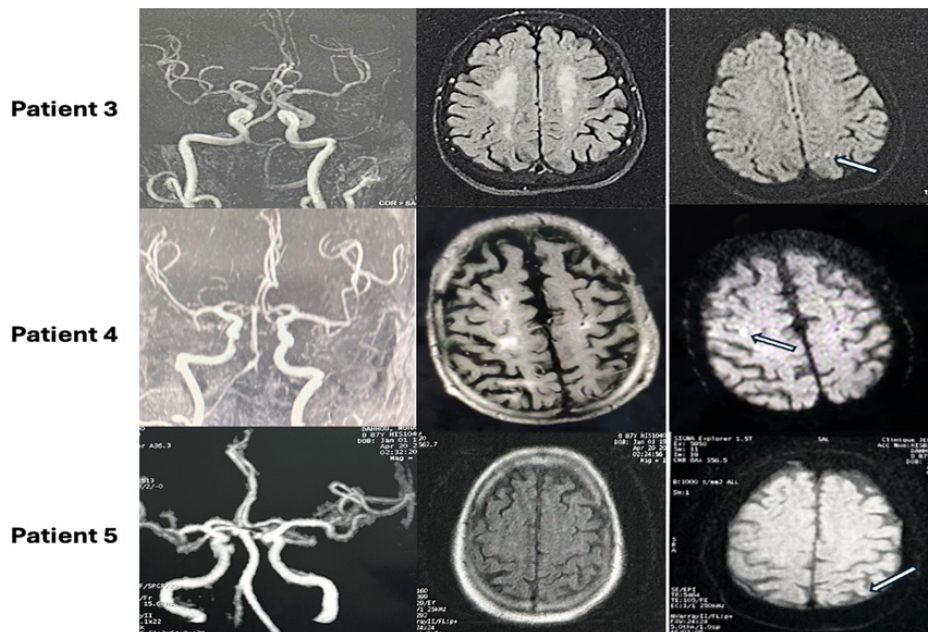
Brain MRI showing cortical infarcts in frontal and parietal lobes for Cases 3, 4 and 5. (arrows).
